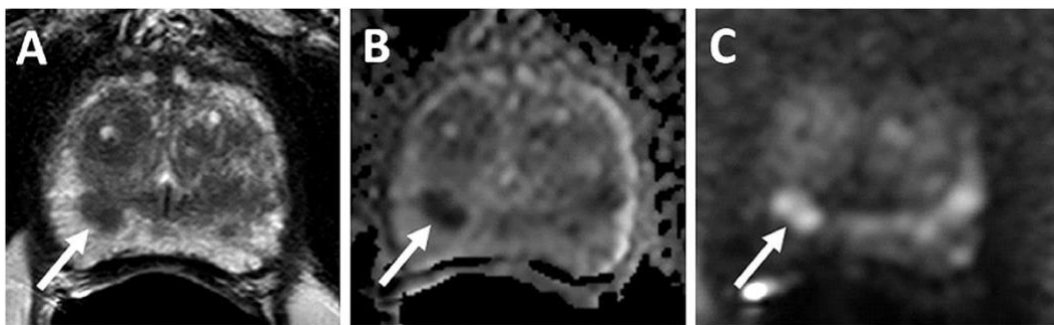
Multiparametric MRI of a 69-year-old man with a PSA of 34.95 ng/mL and the corresponding lesion of the prostate cancer, marked with arrows. (A) T2w sequence, (B) ADC map, (C) B-2000 DWI. Obtained from (21)
